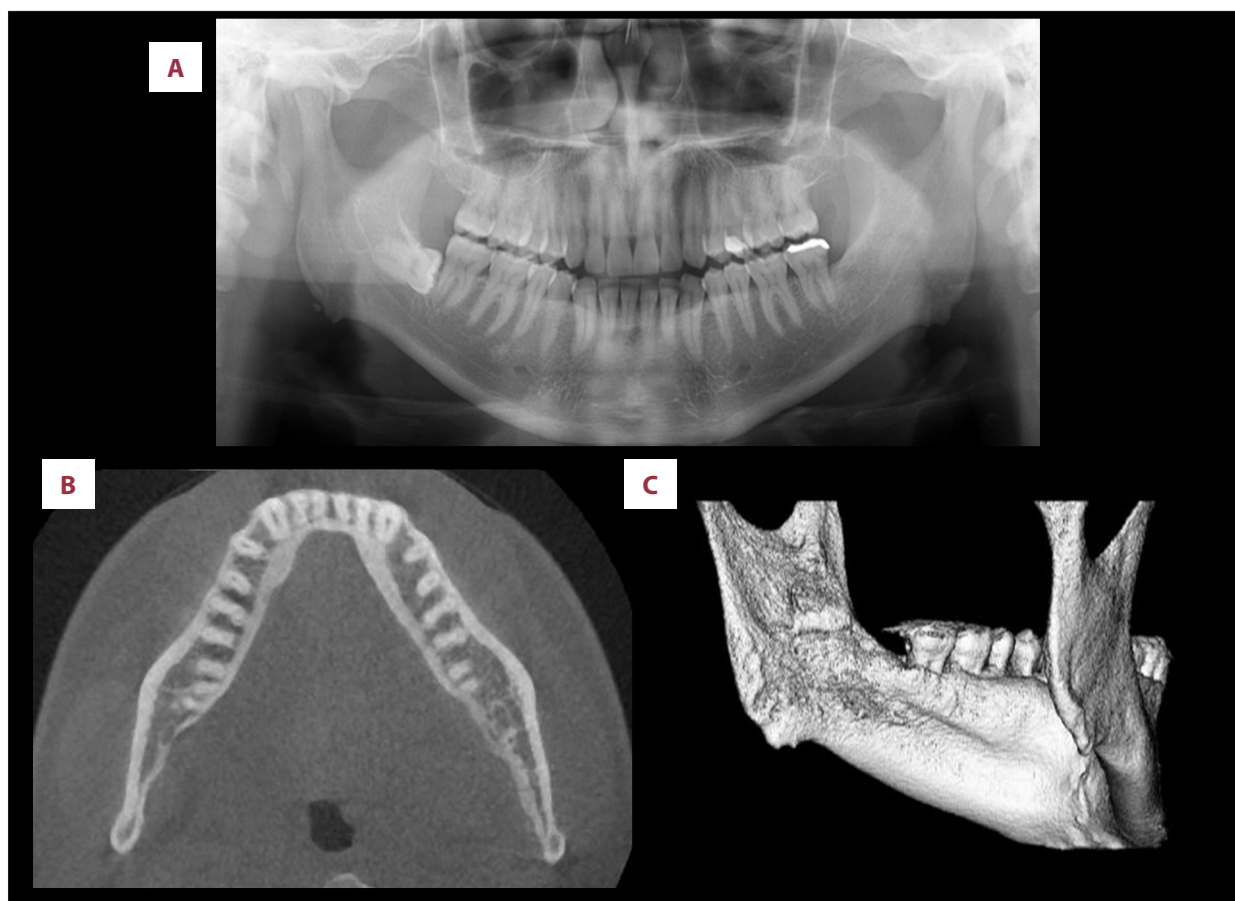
Postoperative imaging. (A) Panoramic radiograph showing complete removal of the tooth fragment. (B) Axial CBCT image. (C) Three-dimensional CBCT image.
